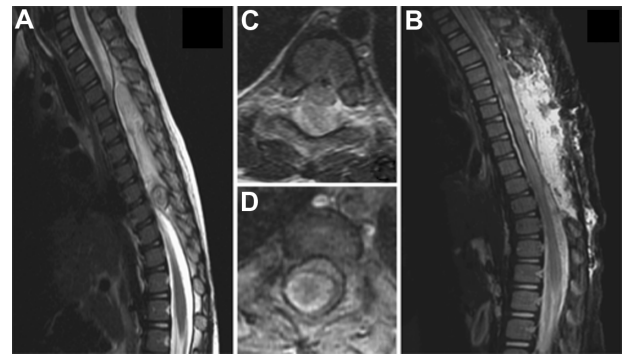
Pre-operative thoracolumbar spinal MR image detailing a 7.5 mm × 14 mm × 14 mm elongated cystic mass, with mixed T2 signal intensity in the dorsal epidural space extending from the T3–T10 vertebral levels (A). Post-operative enhancement of the dorsal epidural space in the area of the excised lesion (B). Pre-operatively, there is severe pre-operative spinal cord compression, with the cystic components extending into the T5–T6 and T6–T7 intervertebral foramina (C–D).
